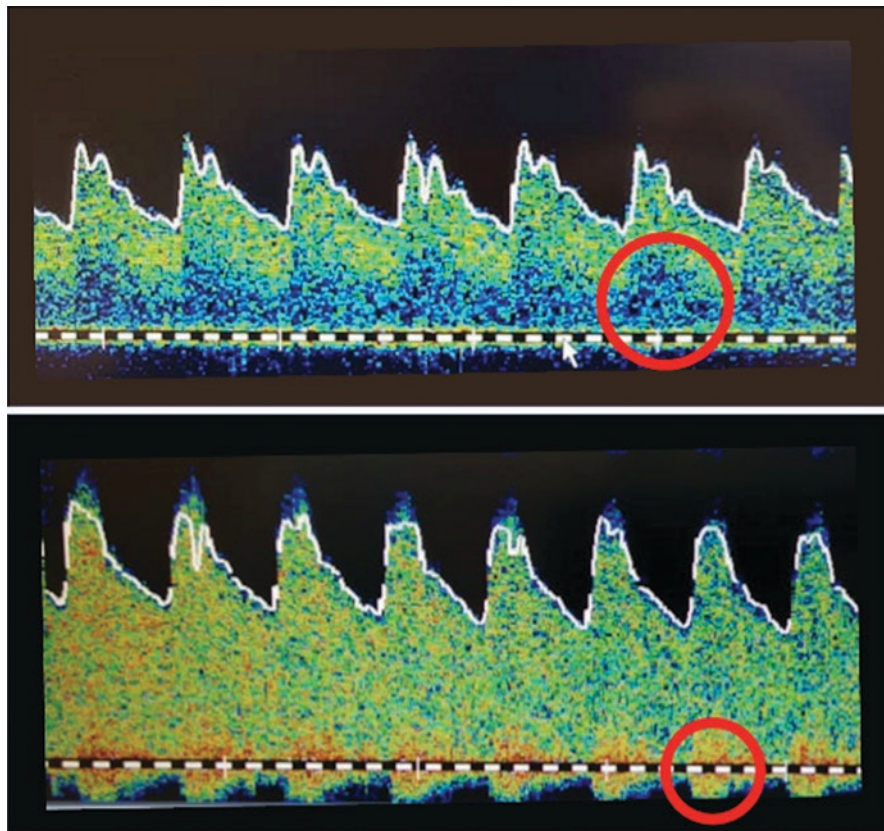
Difference between laminar flow spectrum (upper) and turbulent flow spectrum (lower). In the first one most of the circulating particles are of high velocity and therefore form a thick line near the maximum velocity in each instant; the different colors translate more or less particles concentration. A lower triangle remains where there is a spectral window, indicated by a red circle. In turbulent flow, which can be seen in bifurcations, or in severe stenoses, the angles of intonation are formed between the direction of the particles rotating in turbulent form and the direction of the ultrasound emitted by the transducer are large, so they look as low velocities. The vascular murmur is marked with a circle, evidencing the turbulence, which has a special sound, like that of a "seagull's song", superimposed on the normal sound
